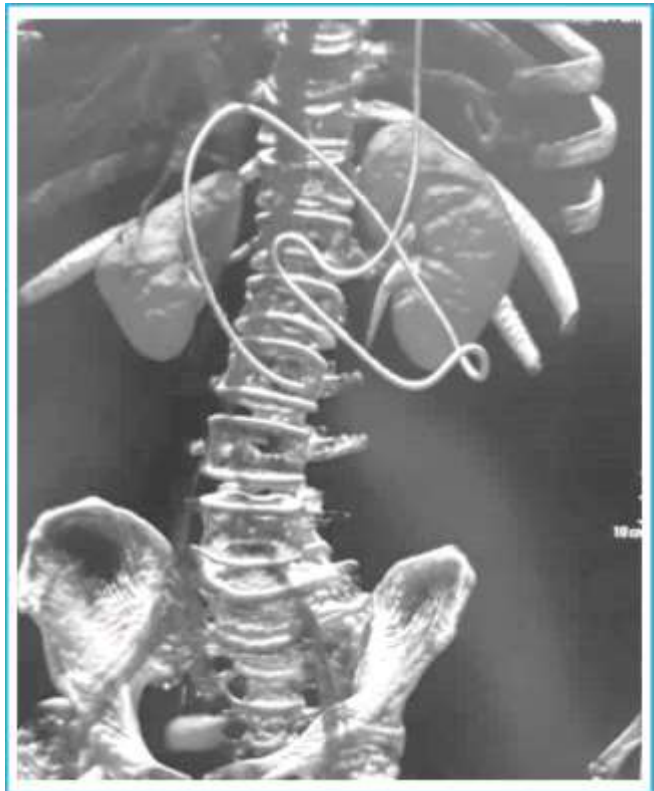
CT scan 3-D reconstruction of the abdomen showing the peritoneal tube of the VP Shunt with no evidence of kinking.
